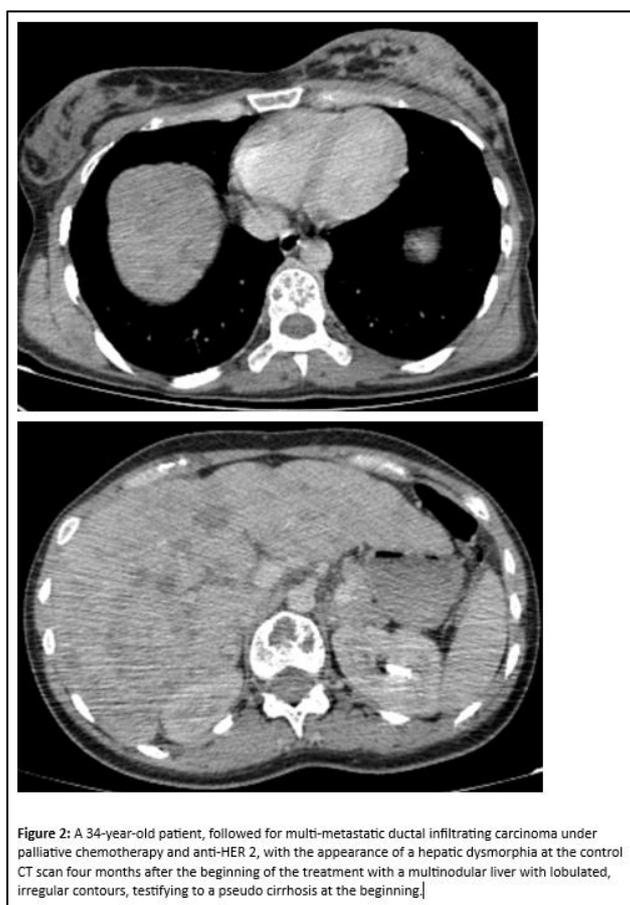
A 34-year-old patient, followed for multi-metastatic ductal infiltrating carcinoma under palliative chemotherapy and anti-HER 2, with the appearance of a hepatic dysmorphism at the control CT scan four months after the beginning of the treatment with a multinodular liver with lobulated, irregular contours, testifying to a pseudo cirrhosis at the beginning.]
